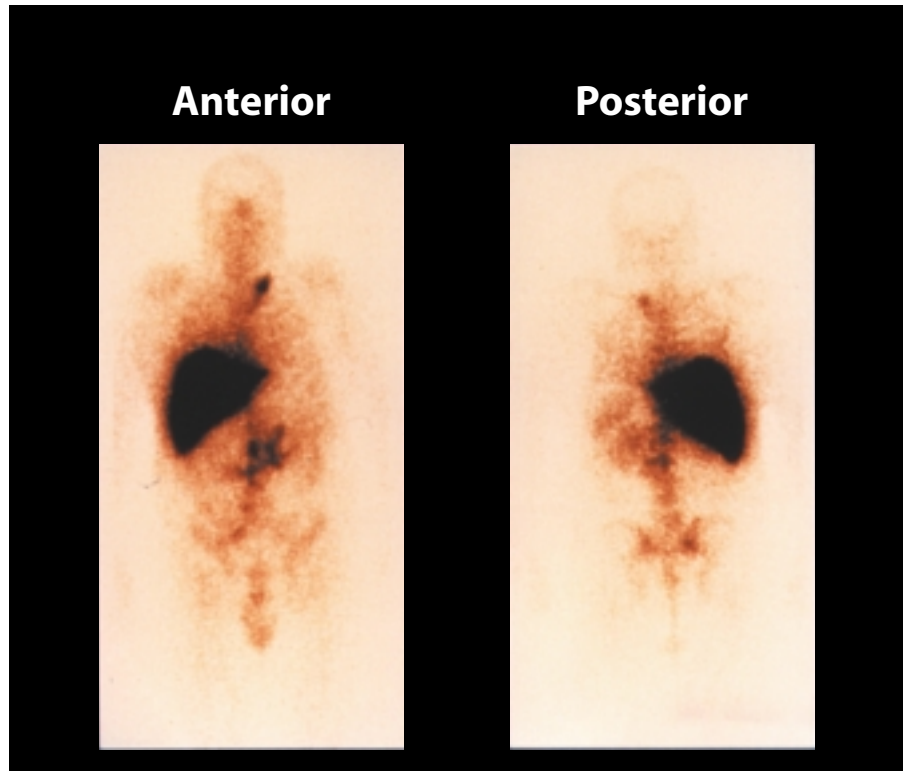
Immunoscintigraphic (¹¹¹Indium (In)-capromide pendetide) scanning. Image represents para-aortic and left clavicular evidence of systemic recurrence of prostate cancer following radical prostatectomy in a man with an isolated biochemical recurrence. Large shaded area represents accumulation of radiotracer in the liver. (Images provided by Dr. Michael Haseman).
